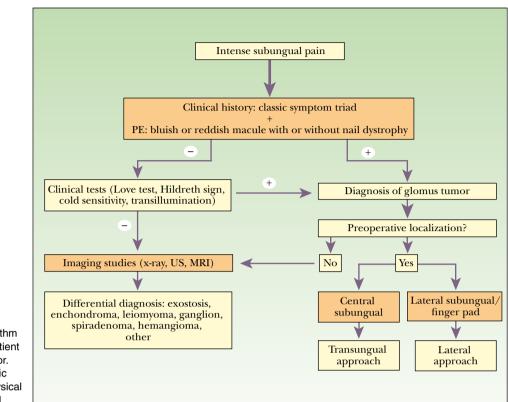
Treatment algorithm for the management of a patient with suspected glomus tumor. Abbreviations: MRI, magnetic resonance imaging; PE, physical examination; US, ultrasound.
